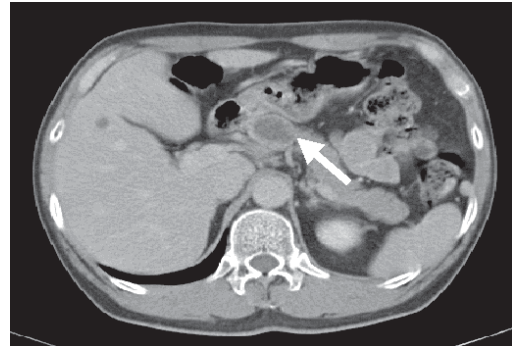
Triphasic CT scan abdomen showing a 3.0 x 2.3 cm pancreatic lesion (arrow).
